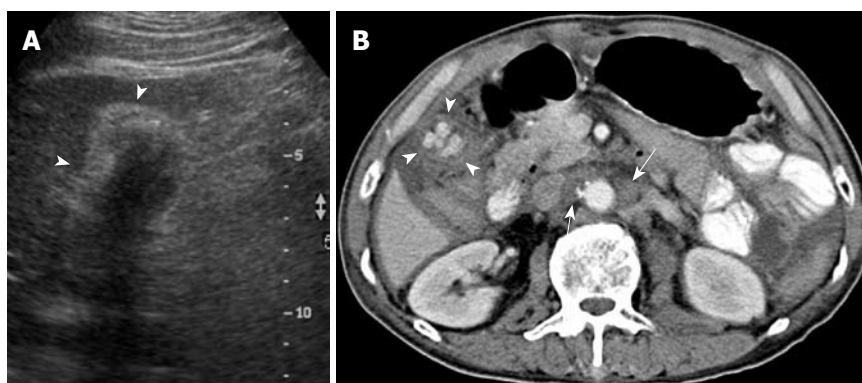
A 78-year-old man admitted to the emergency room with right upper abdominal pain, fever and jaundice for 1 d. A: US showed a contracted gallbladder with a thickened wall (arrowheads) and multiple gallstones that obliterated underlying details, which mimicked chronic cholecystitis; B: Contrast-enhanced CT showed a relatively small gallbladder with uneven wall thickening (arrowheads), multiple gallstones and pericholecystic inflammatory stranding and fluid suggestive of gallbladder carcinoma (GBCA), with coexistent acute cholecystitis. Note the intercavaortic and left para-aortic lymph node metastasis (white arrows).
